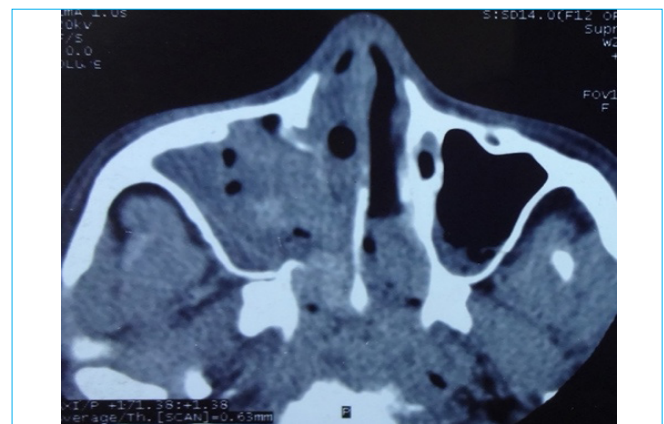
CT scan of nose and PNS finding
